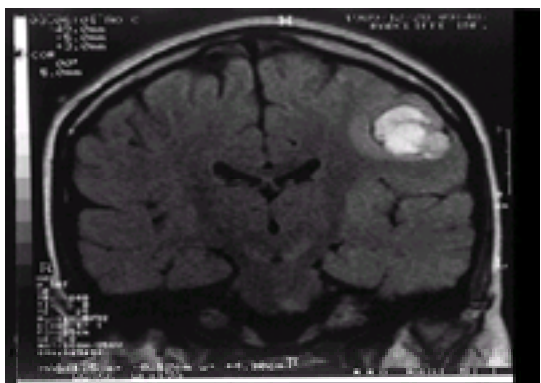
Coronal MRI of the same patient shown in Fig. 24.
